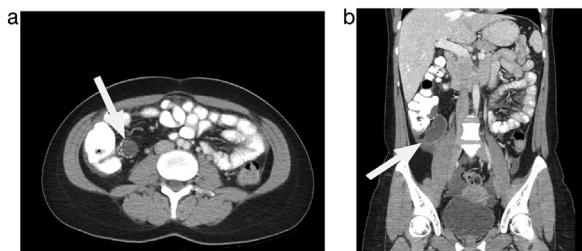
(A) Axial and (B) coronal reformatted contrast-enhanced CT images of the abdomen. Arrow depicts the cystic mass adjacent to the ascending colon.
